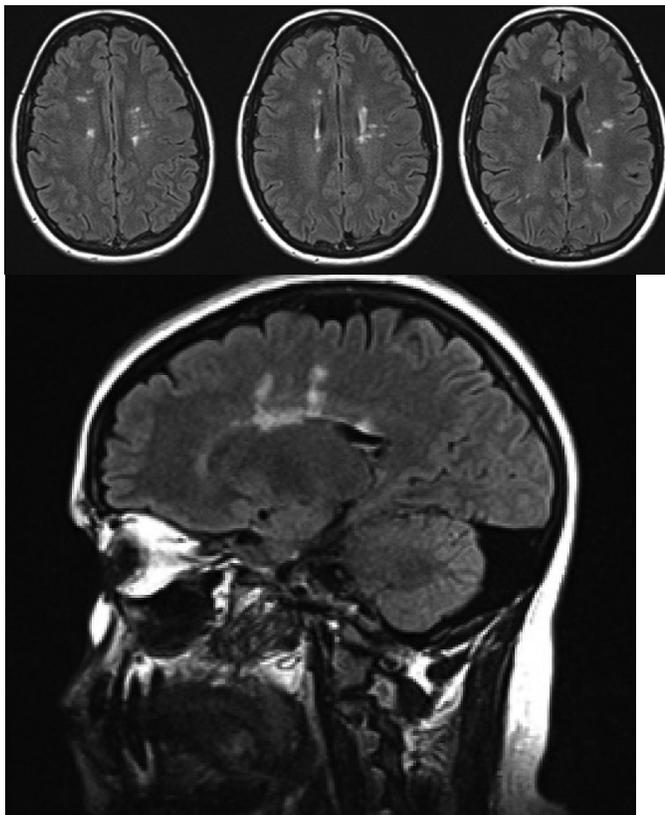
Axial (A) and sagittal (B) T2 - FLAIR sequence showing multiple "Dawson's Fingers": vertically oriented ovoid periventricular white matter lesions.
